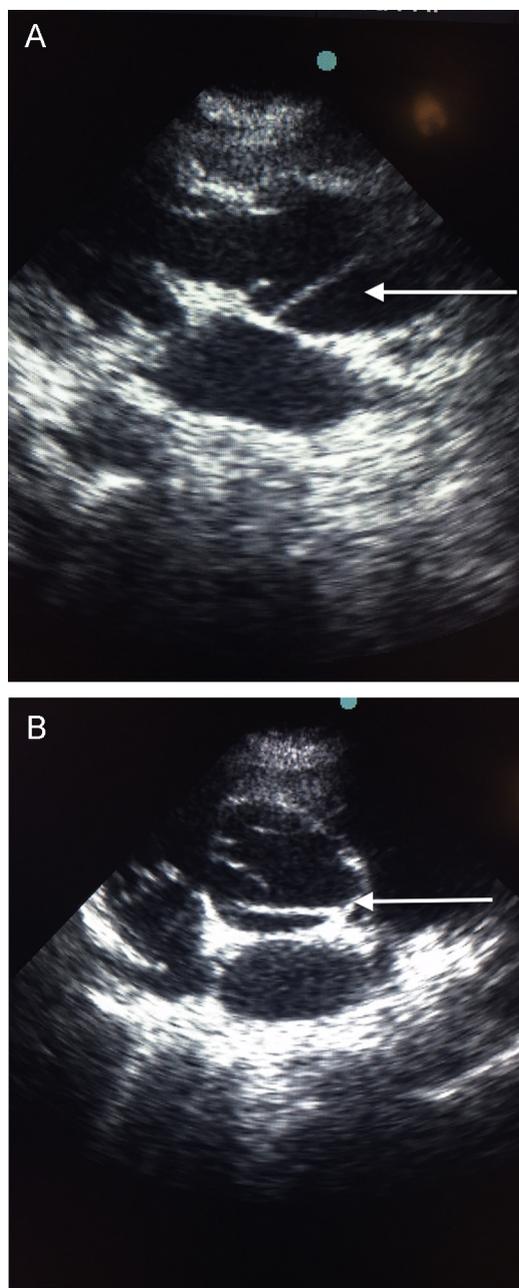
(A) Transthoracic 2D echocardiogram in parasternal long axis view showing aortic dissection flap (white arrow) just above the level of the aortic valve. (B) Transthoracic 2D echocardiogram in short axis view demonstrating dissection flap separating the true and false lumen almost at the aortic valve leaflets level (white arrow).
